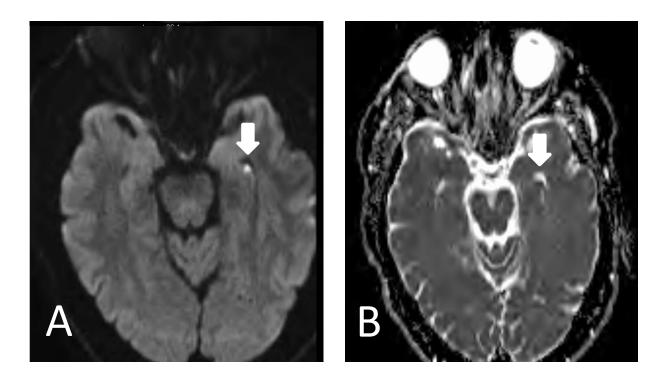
MRI Brain with DWI (panel A) and ADC (Panel B) sequences demonstrating punctate area of diffusion restriction in the left lateral hippocampus 24 hours post first presentation with TGA.
